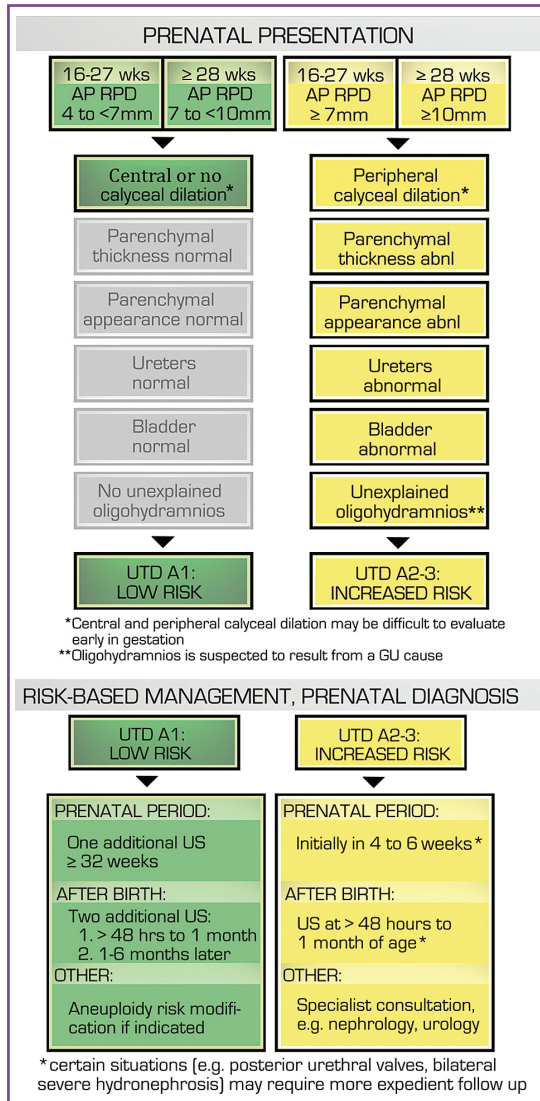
Urinary tract dilatation (UTD) prenatal risk stratification and risk-based management. Prenatal UTD grade A1 indicates low risk, and UTD grades A2 and A3 indicate increased risk. Stratification is based on the most concerning feature demonstrated at ultrasonography. AP, anteroposterior; GU, genitourinary; RPD, renal pelvic diameter; US, ultrasonography.
